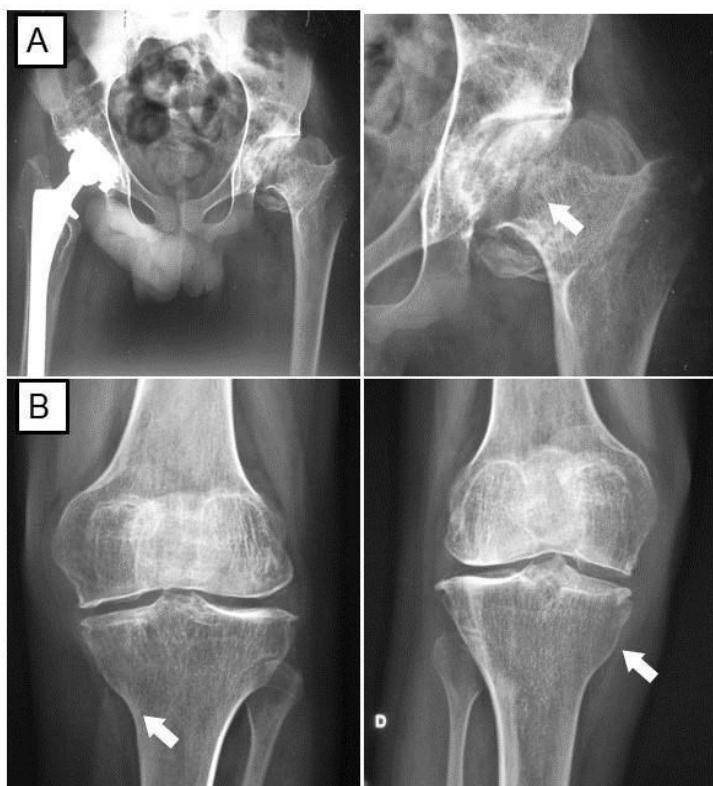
Bilateral hip and knee X-ray showing osteonecrosis of the femur head and right prosthesis (A) and osteopenia (B).
